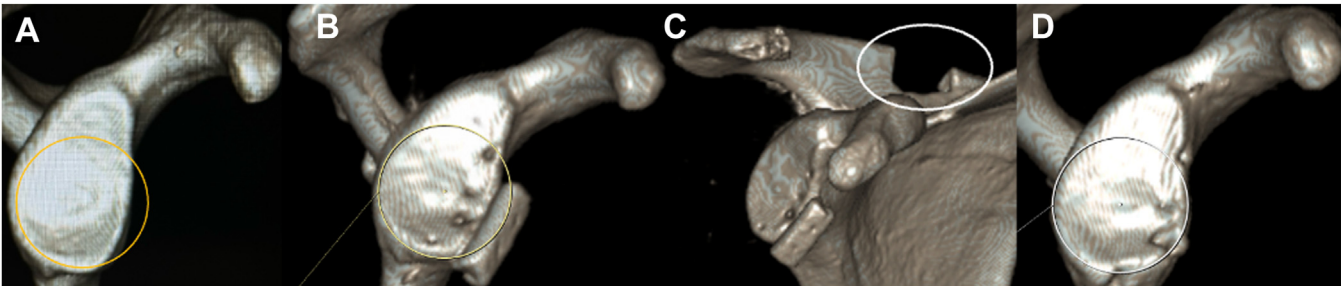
Glenoid surface area results from patient #2. A 3D computed tomography scan of the right shoulder in sagittal view with the best-fit circle is presented. (A) The preoperative view revealed slight anterior glenoid bone loss. (B) The postoperative view indicated that the scapular graft extended beyond the best-fit circle. (C) The graft was flush against the glenoid surface and the harvesting site of the spinal scapula. (D) Two years postoperatively, graft remodeling reconstructed the glenoid shape. 3D, three-dimensional.
